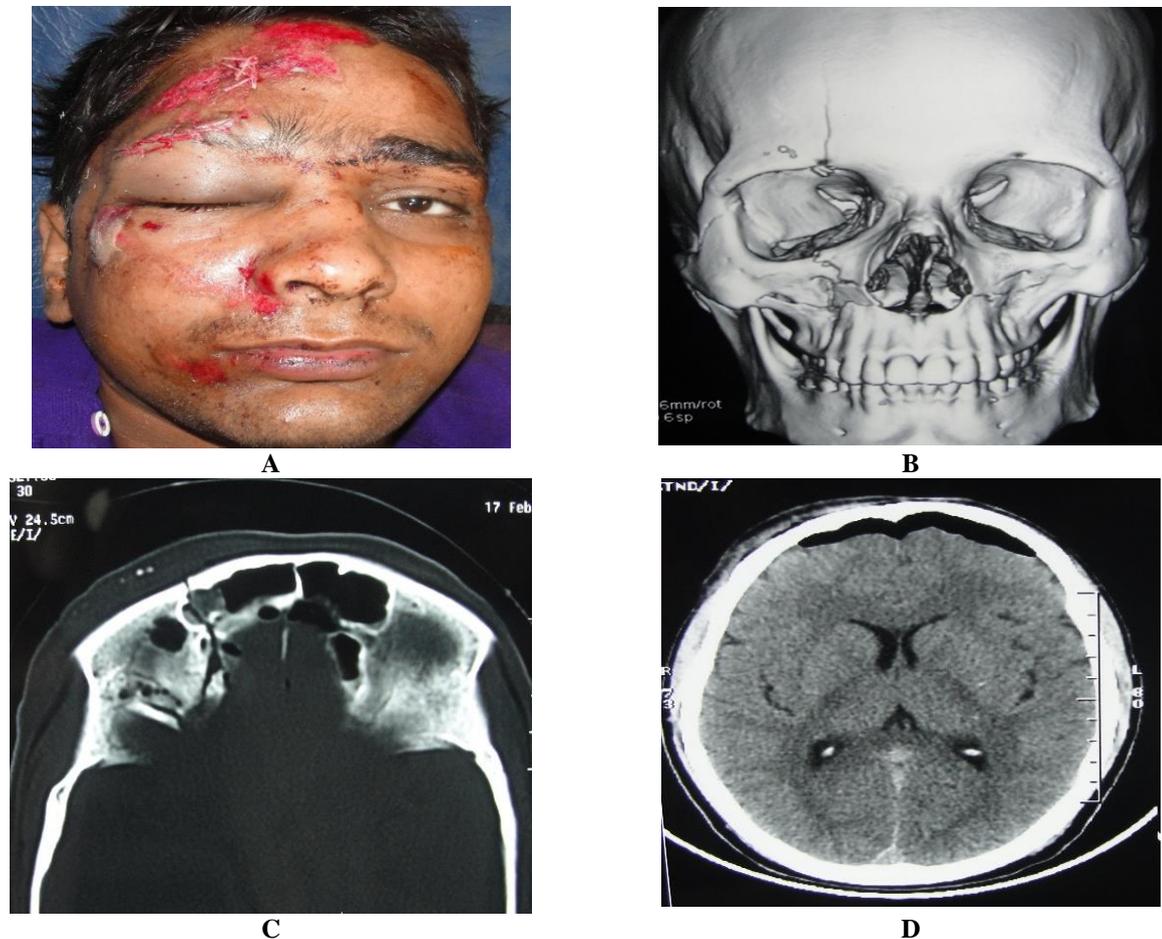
A young male patient with history of road traffic accident with eyelid, facial & forehead abrasion, axial bone window CT orbit, CT cranium & frontal 3D volume rendered CT image projection with bone thresholding showing fracture right maxillary and frontal bones involving floor & roof of right orbit. The frontal pneumocephalus present
